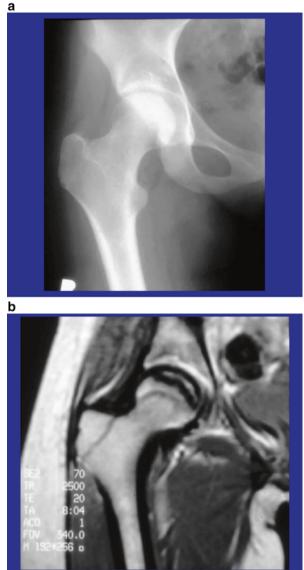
Images of a young male with Stage I steroidinduced osteonecrosis of right hip. (a) Plain radiograph appears "normal." (b) T1 Weighted MRI shows characteristic changes of ON
